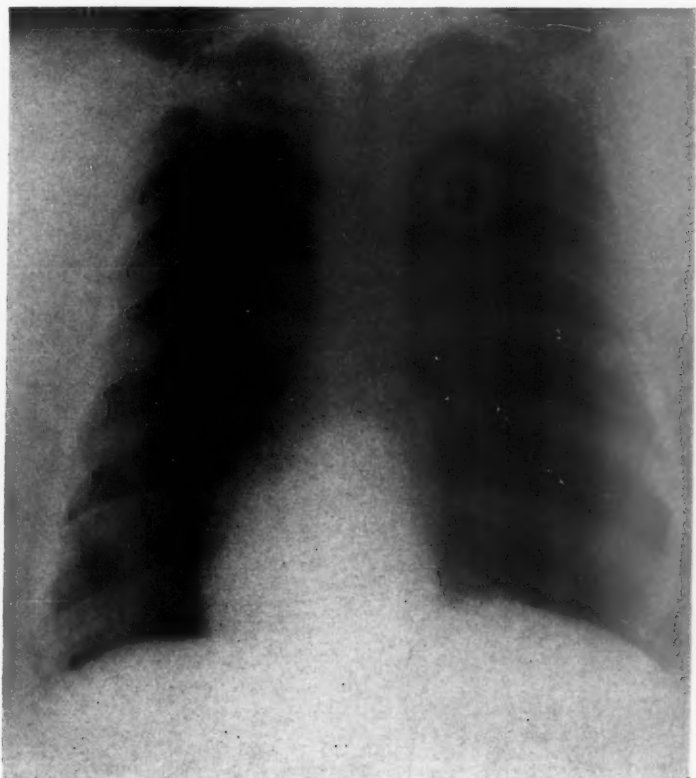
X-ray of the chest (1947), revealing no abnormality of the heart or lung.
